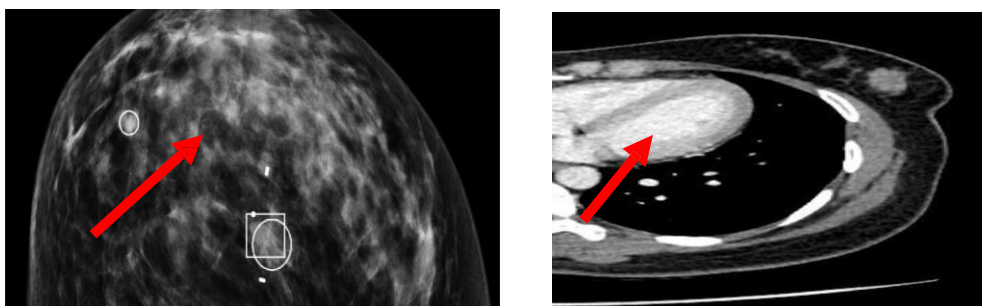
Mammography: Dense opacity is seen in left breast at lower inner quadrant with irregular margins. b) CT Scan: An irregular soft tissue intensity enhancing lesion is seen in lower quadrant of left breast measuring 17×19mm.
